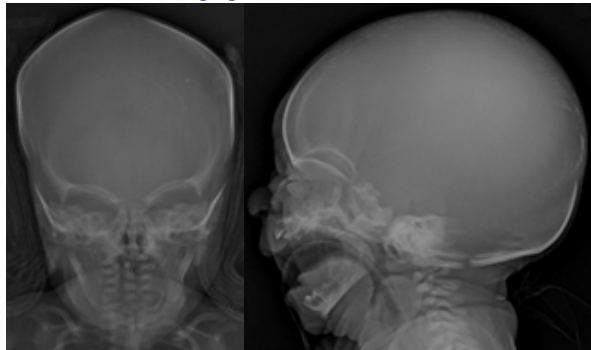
Radiographs of Head - AP/ LATERAL views showing large sized head with thin skull bones, widened fontanelles and J shaped sella, while the facial bones appear normal.
